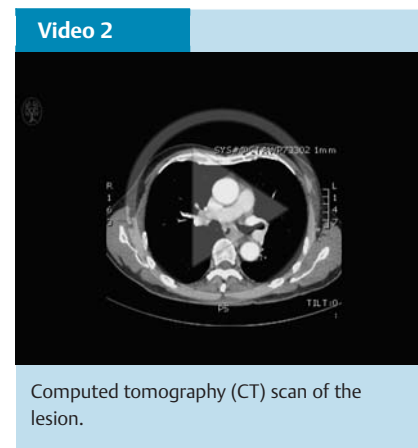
Computed tomography (CT) scan of the lesion, which was suggestive of benign tumors.
